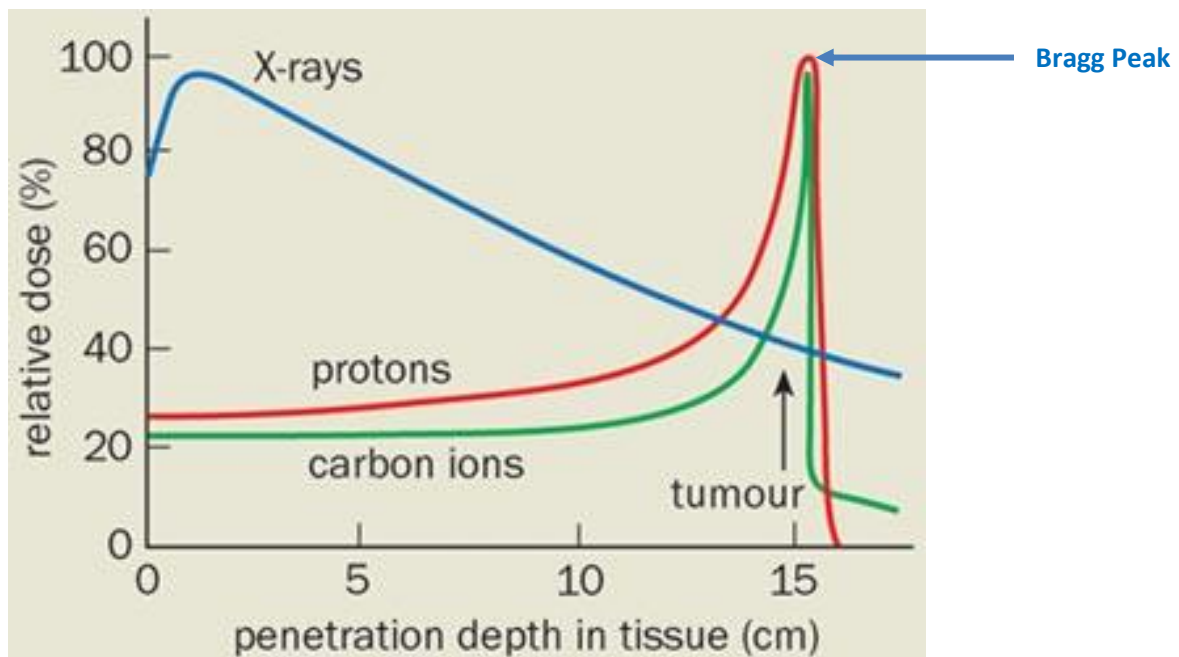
X-rays lose energy rapidly as they travel through the body. Protons and other ions deposit most of their energy at a specific depth depending on their energy (the Bragg Peak). Therefore, they can deliver a high radiation dose at a tumour site, sparing surrounding healthy tissue.¹⁵
